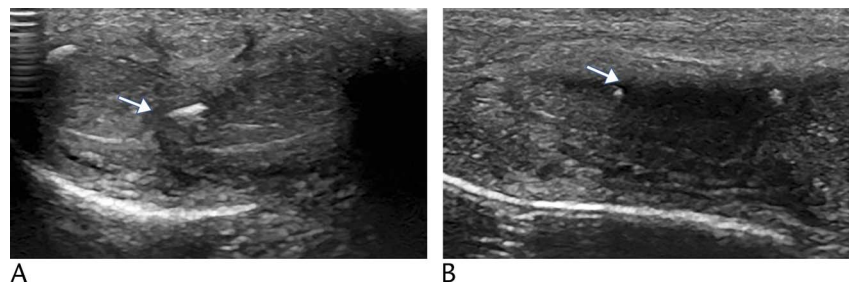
A 58-year-old man with Peyronie disease. Patient presents with a compliant of erectile dysfunction and an irregular curvature of the penis. A, Transverse grayscale sonogram demonstrating a calcified plaque (arrow) along the tunica albuginea. B, Sagittal gray scale sonogram of the same patient.
